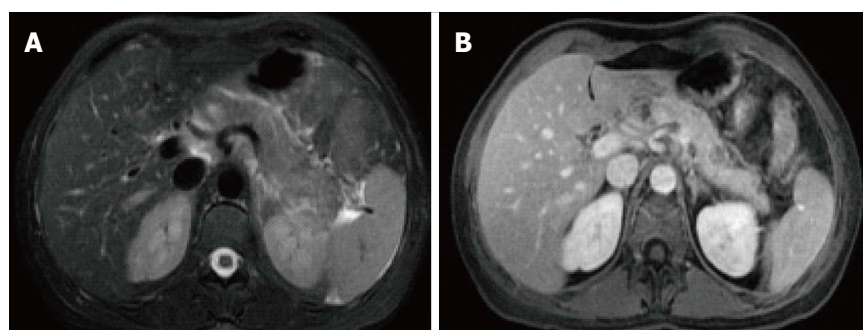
Focal acute necrotizing pancreatitis. A: Axial fast spin-echo T2-weighted image with fat-suppression; B: Axial post-contrast 3D-GRE T1-weighted images with fat-suppression during the venous phase. There is a focal area of low T2 signal involving the proximal part of the pancreatic tail, associated with minimal peripancreatic fat stranding (A). This focal area demonstrates significantly reduced enhancement on the post-contrast images, in keeping with focal necrotizing pancreatitis.
